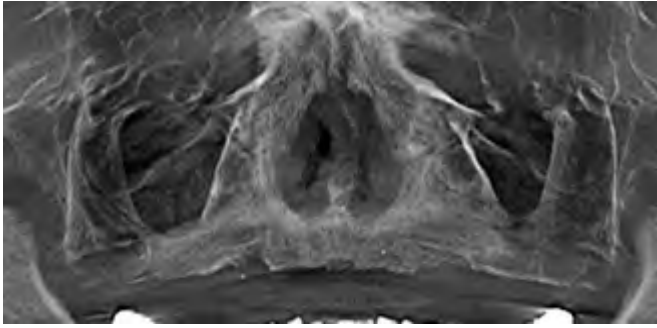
Panoramic radiograph prior to implant placement. There appeared to be adequate bone volume throughout the entire maxillae for the placement of multiple implants to support a fixed prosthesis.
